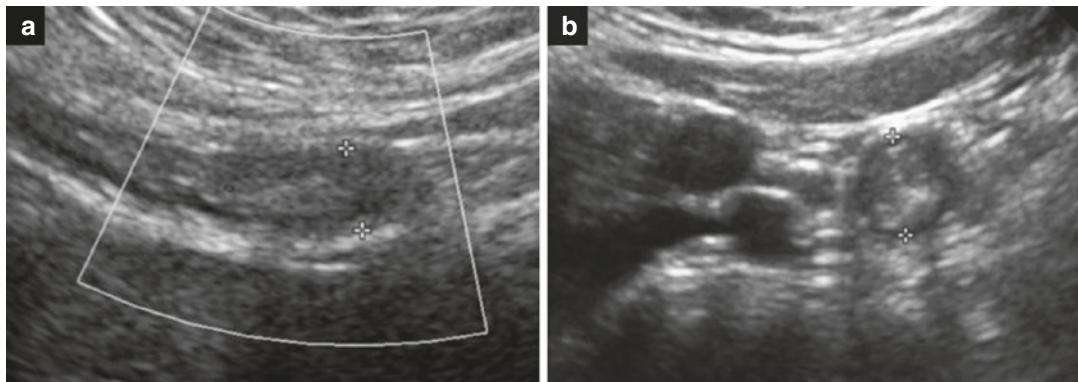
Transverse (a) and sagittal (b) sonograms show an inflamed appendix (between cursors). European Radiology, Added value of ultrasound re-evaluation for patients with equivocal CT findings of acute appendicitis:
